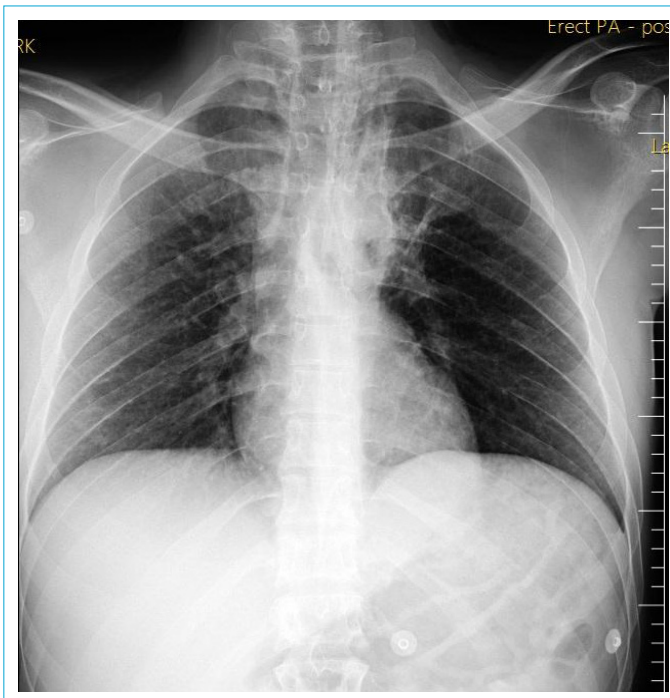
Subcutaneous emphysema in the cervical region is observed in PA chest X-ray.
